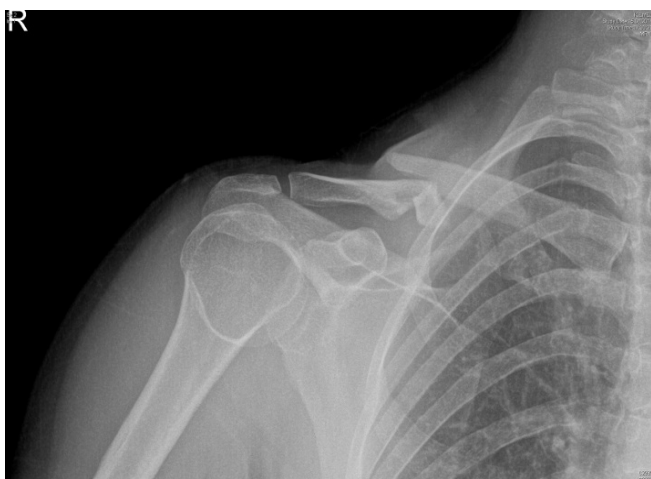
42 years woman's shoulder AP x-ray image showing that clavicle comminuted fracture
